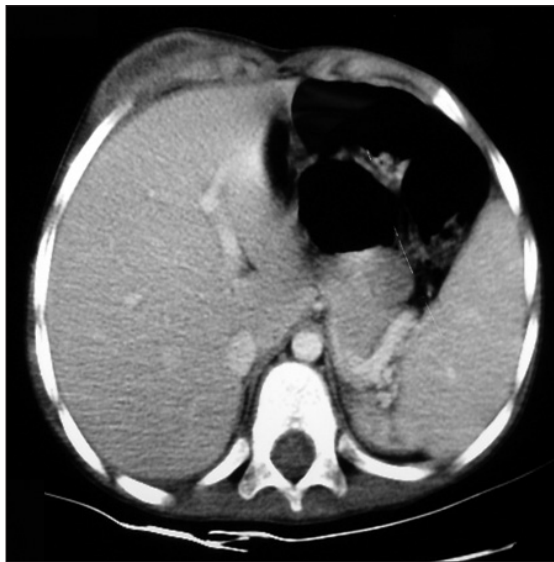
CT scan of the chest revealed a left chest wall mass with layering effects.
